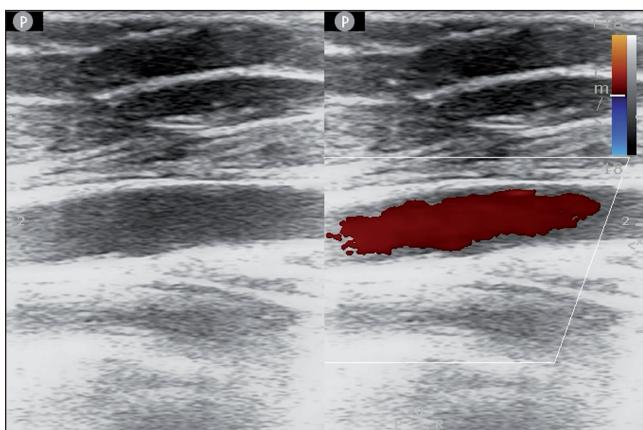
Doppler ultrasound of the left common femoral artery showed slow flow.
